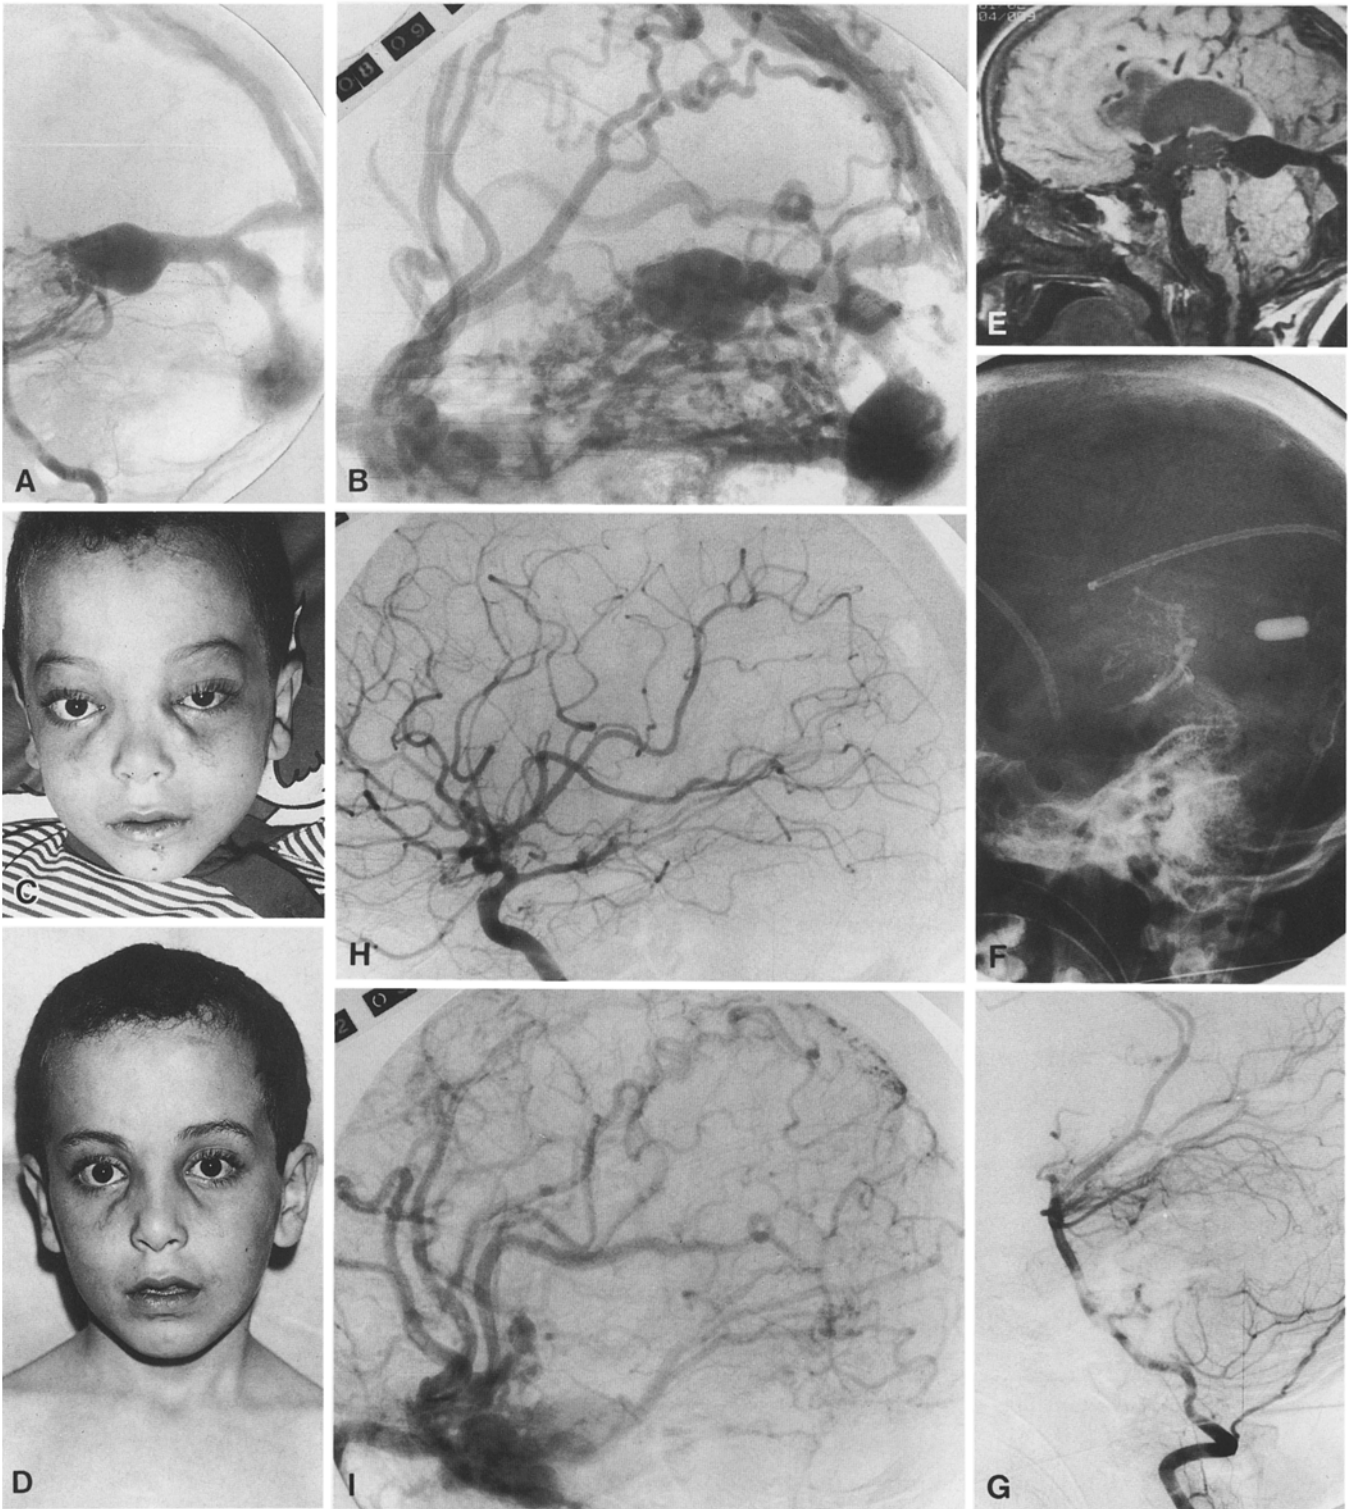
A–I. Vertebral angiogram in early (A) and late (B) phase in a case of choroidal type of vein of Galen arteriovenous malformations (VGAM); distal spontaneous sinus occlusion re-routes both the arteriovenous malformation and normal brain venous flow to the facial veins (C). Following three arterial embolization sessions, flow reduction is obtained with concomitant improvement of the facial vein circulation (D). In view of the remaining retrograde cerebral flow, the venous approach is carried out by transthoracic
